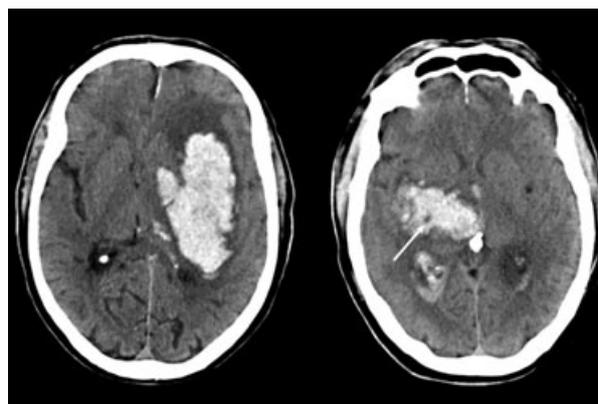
Examples of baseline unenhanced CT scans. Left: intracerebral hemorrhage without swirl sign. Right: the swirl sign represents actively extravasating unclotted fresh blood (arrow) which is of lower attenuation than clotted blood (typically 50–70 HU) which surrounds it. It represents active bleeding in the hematoma.
